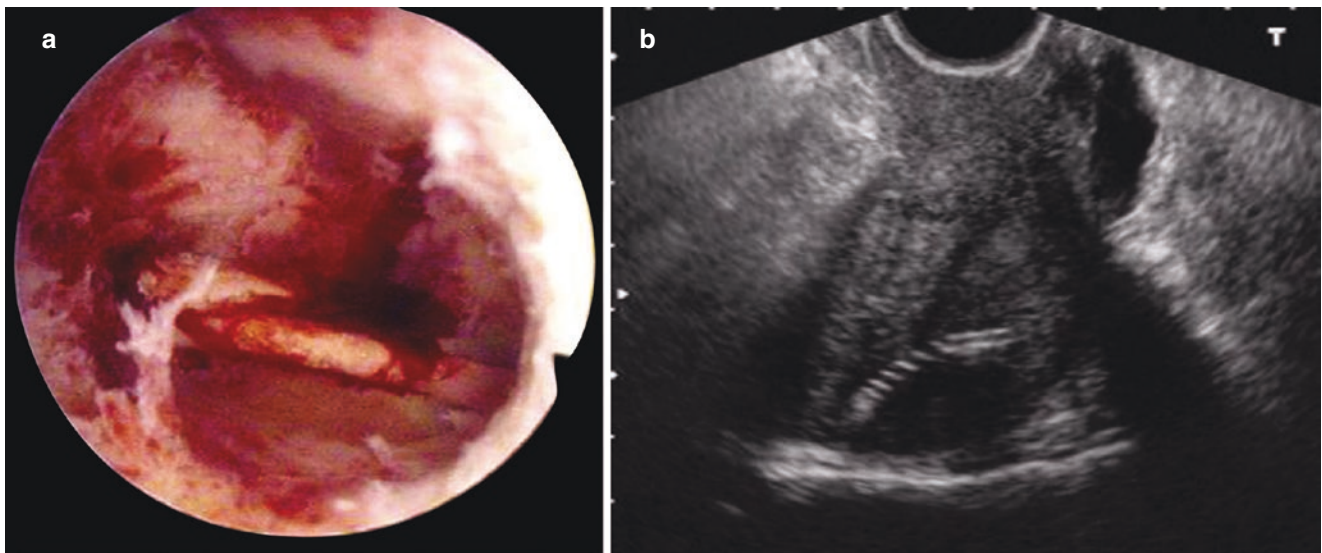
incarceration of IUD. (a) Only part of IUD is shown in the uterine cavity under the examination of hysteroscopy. (b) Ultrasound examination shows that part of the hyperechoic IUD is inserted into the muscular layer
